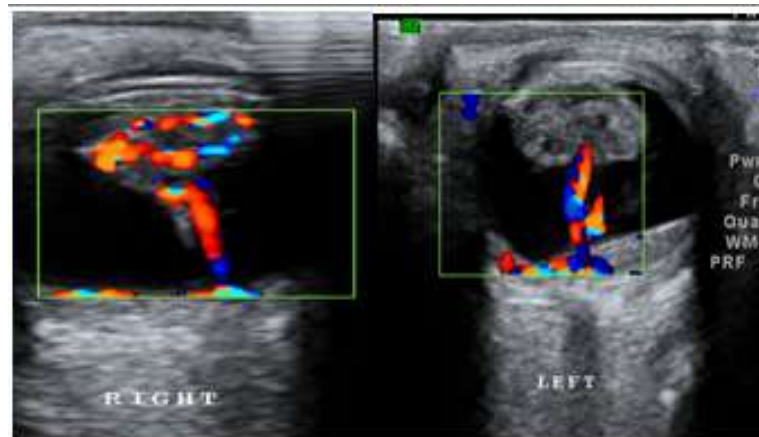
Axial B scan in a 3month old baby presenting with bilateral leukocoria suspected of retinoblastoma, Gray scale with Doppler demonstrates typical appearance of PHPV.
